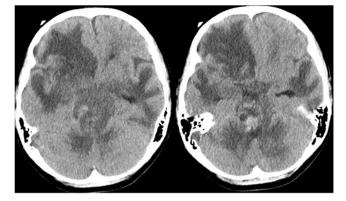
CT scan of the brain showing interval expansion of the intraparenchymal hemorrhage within the pons, with compression of the fourth ventricle. Multiple areas of brain edema in the right and left cerebral hemispheres, cerebellar hemispheres, thalami, as well as the midbrain and pons are also shown.
